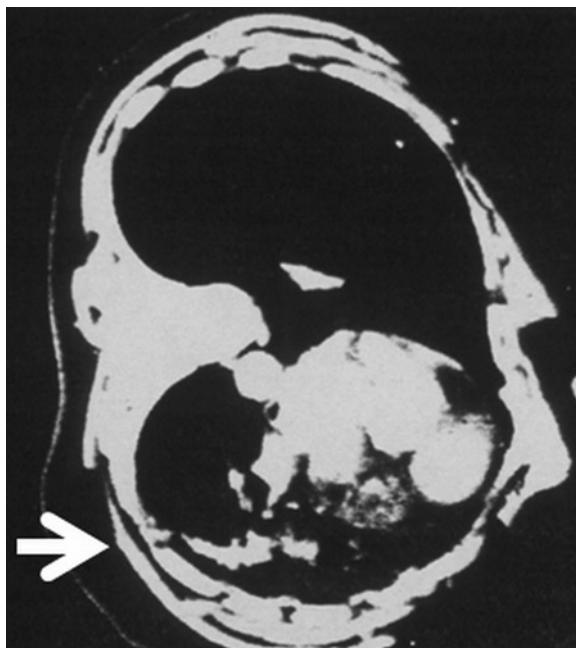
Chest CT scan during general anesthesia in the lateral position. The white arrow points to a plaque of atelectasis in the dependent lung. Most patients develop atelectasis in the dependent lung during anesthesia.
